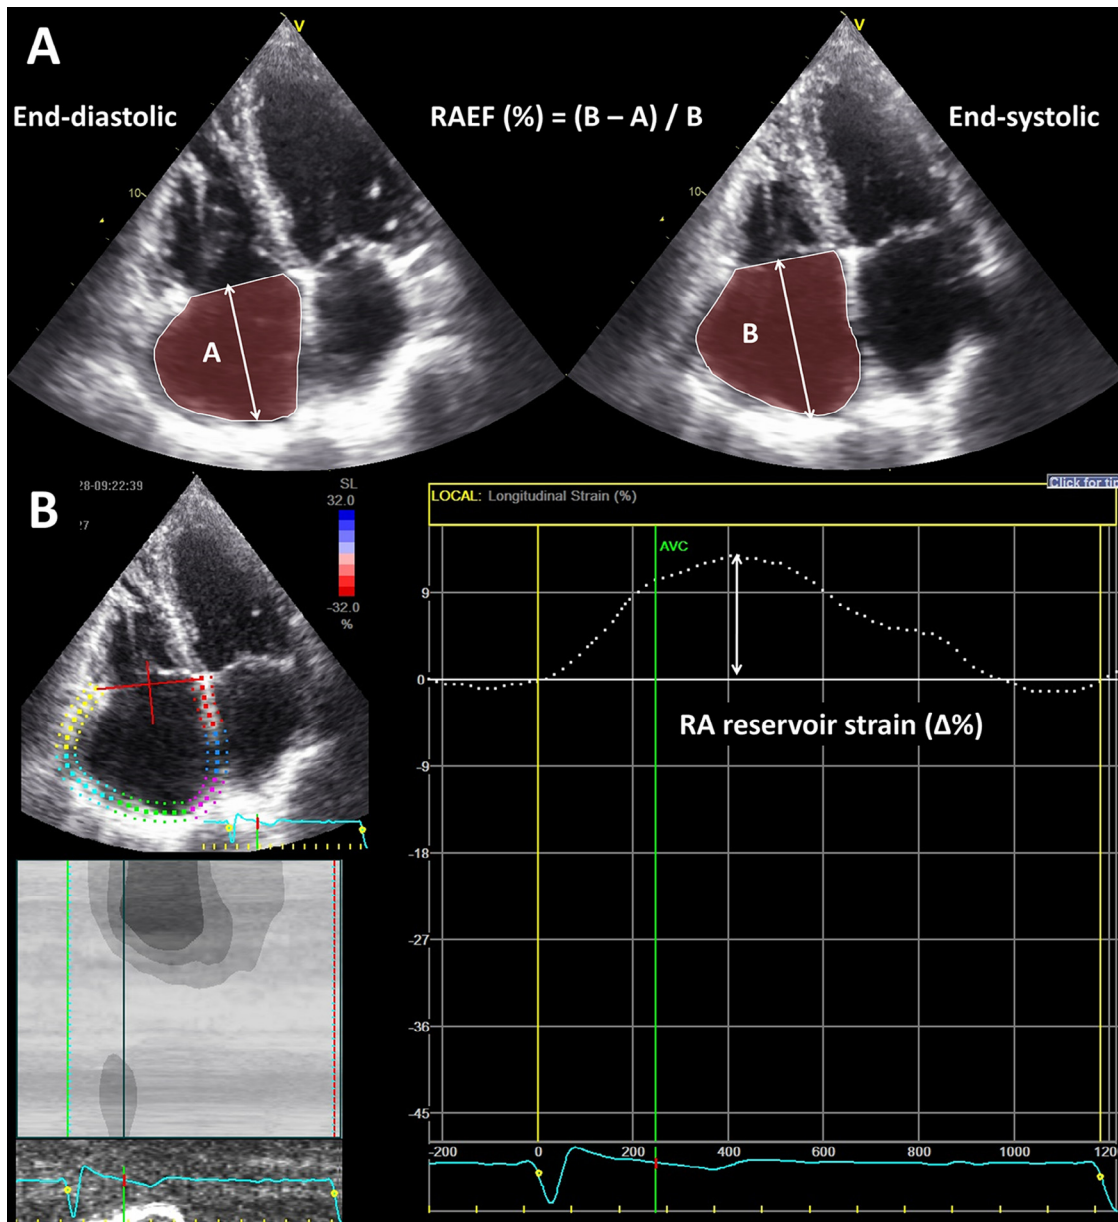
Echocardiographic methods for the assessment of right atrial (RA) function. (A) Assessment of RA emptying fraction (RAEF) with the use of the area-length method in the apical 4-chamber view, and (B) assessment of RA reservoir strain with the use of echocardiographic 2-dimensional speckle tracking strain.
